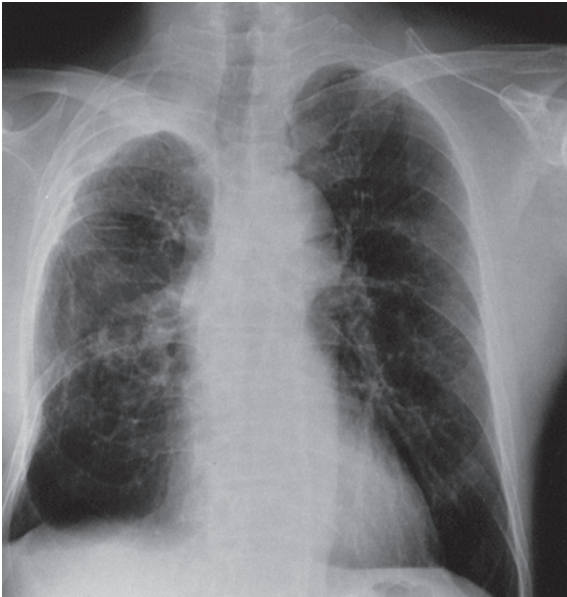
Chest radiograph obtained four months after increase of the steroid dosage shows complete resolution of the left midzone consolidation with mild residual scarring.
